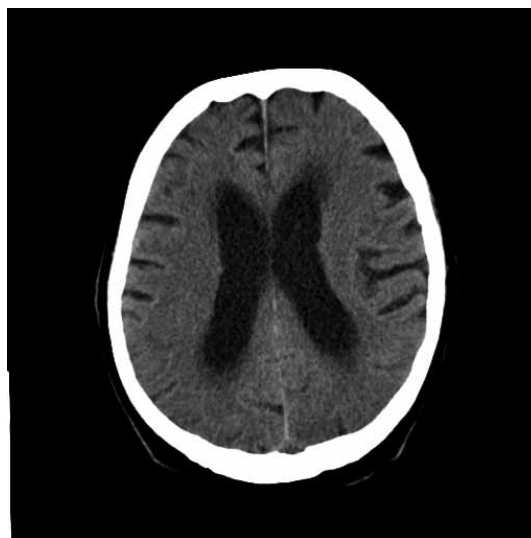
Normotensive hydrocephalus on multi-slice computed tomography.
